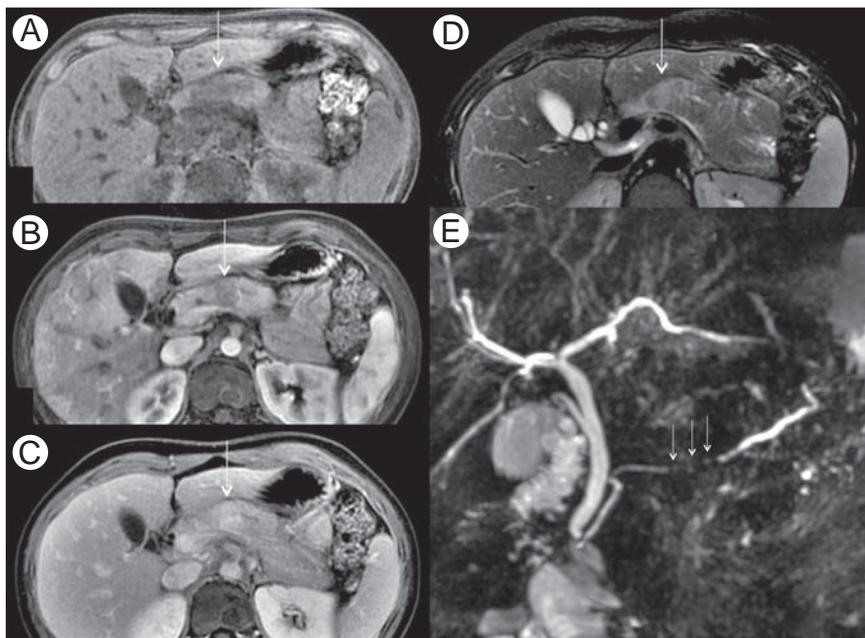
Pseudotumoral acute pancreatitis confirmed by endoscopic ultrasound-guided fine-needle aspiration biopsy in a 19-year-old woman with abdominal pain, elevated serum levels of amylase, lipase, and CA19-9 = 102 (normal <37 U/ml). Axial T1-W 3D GRE images in the unenhanced (A), arterial (B) and portal venous phases (C) show a relatively well-demarcated, hypointense lesion (arrow) in the body of pancreas, with progressive homogeneous enhancement. The lesion has hyperintense signal relative to the pancreas on T2-W fat-suppressed image (D), which also demonstrates slight and diffuse enlargement of the pancreas (arrows). MRCP image (E) shows focally narrowed and irregular main pancreatic duct (arrows) in the affected segment of the pancreas, with mild upstream dilation.
